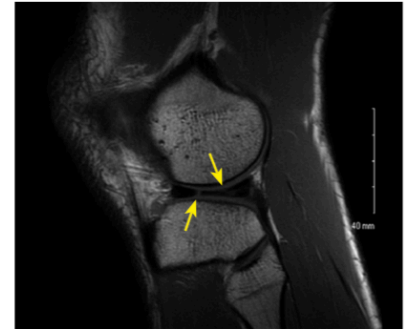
MRI (sagittal view) of a lateral meniscus tear (yellow arrows)
